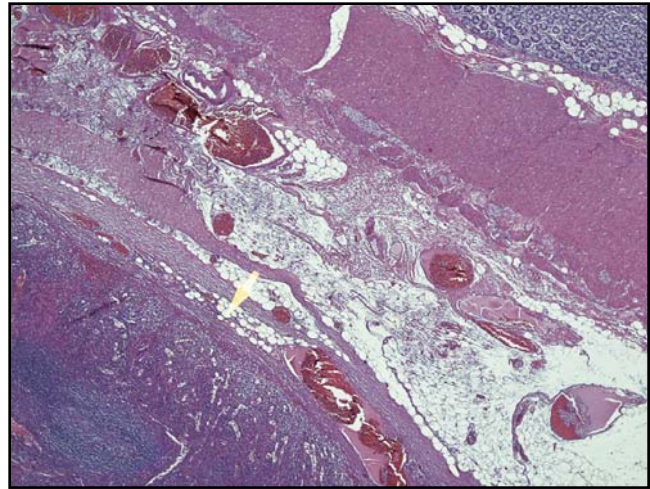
Splenosis adjacent to the colon – corresponding to one of the suspicious lesions observed by ^{68}Ga somatostatin receptor PET/CT.
